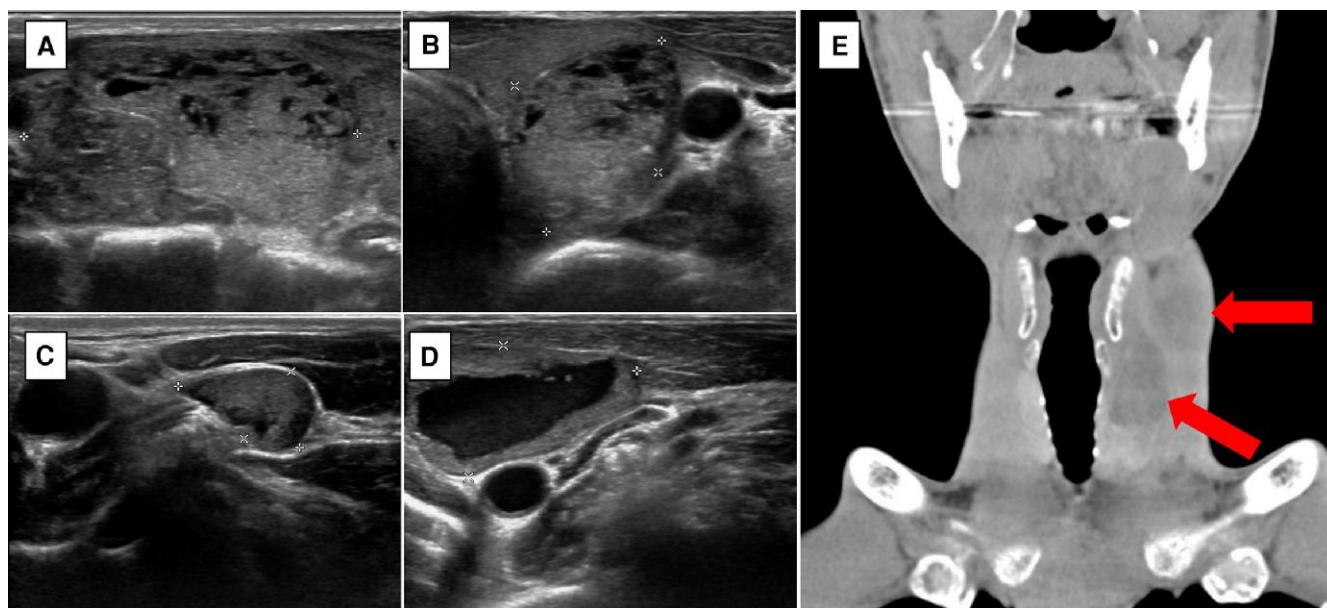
Neck US and CT at the initial presentation. (A, B) Thyroid nodule in the left lobe and left upper pole. (C, D) Malignant lymph nodes in the left side of neck at levels 2 and 3. (E) Neck CT showing masses in the same area as the neck US.
